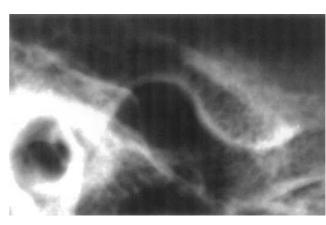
A radiograph of the mandibular fossa taken by the modified Schüller projection
